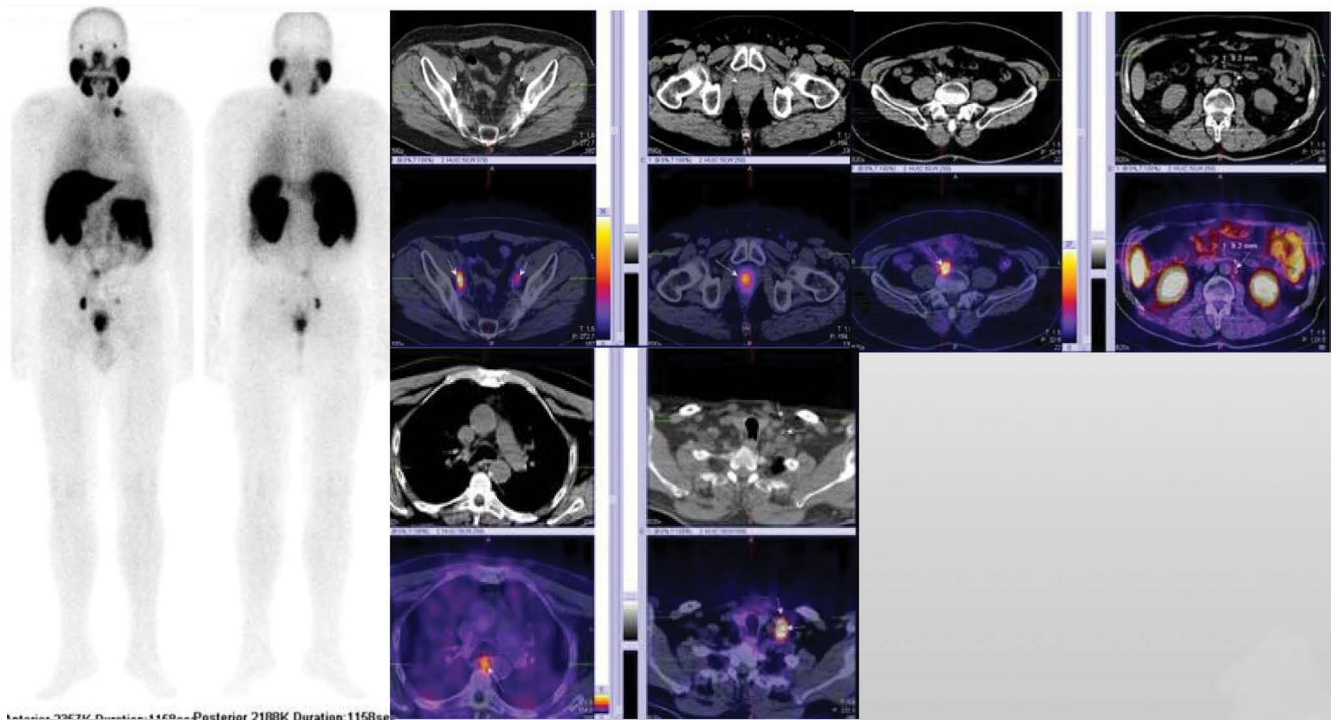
M/64yr with prostate cancer, pT3bpN1Mo, G3, Gl = 9 (5 + 4). Cytreoreductive radiotherapy (01/2018), androgen deprivation therapy, chemotherapy. PSA = 2.157 ng/mL (01/2019). Whole-body scan and target [^{99m}Tc]Tc-PSMA-T4 SPECT-CT imaging showed local recurrence and enlarged bilateral obturator lymph nodes, common iliac lymph node on the right, periaortic with diameter 9.2 mm lymph node, paraesophageal retrotracheal lymph node and supraclavicular lymph node metastases with intensive tracer uptake
